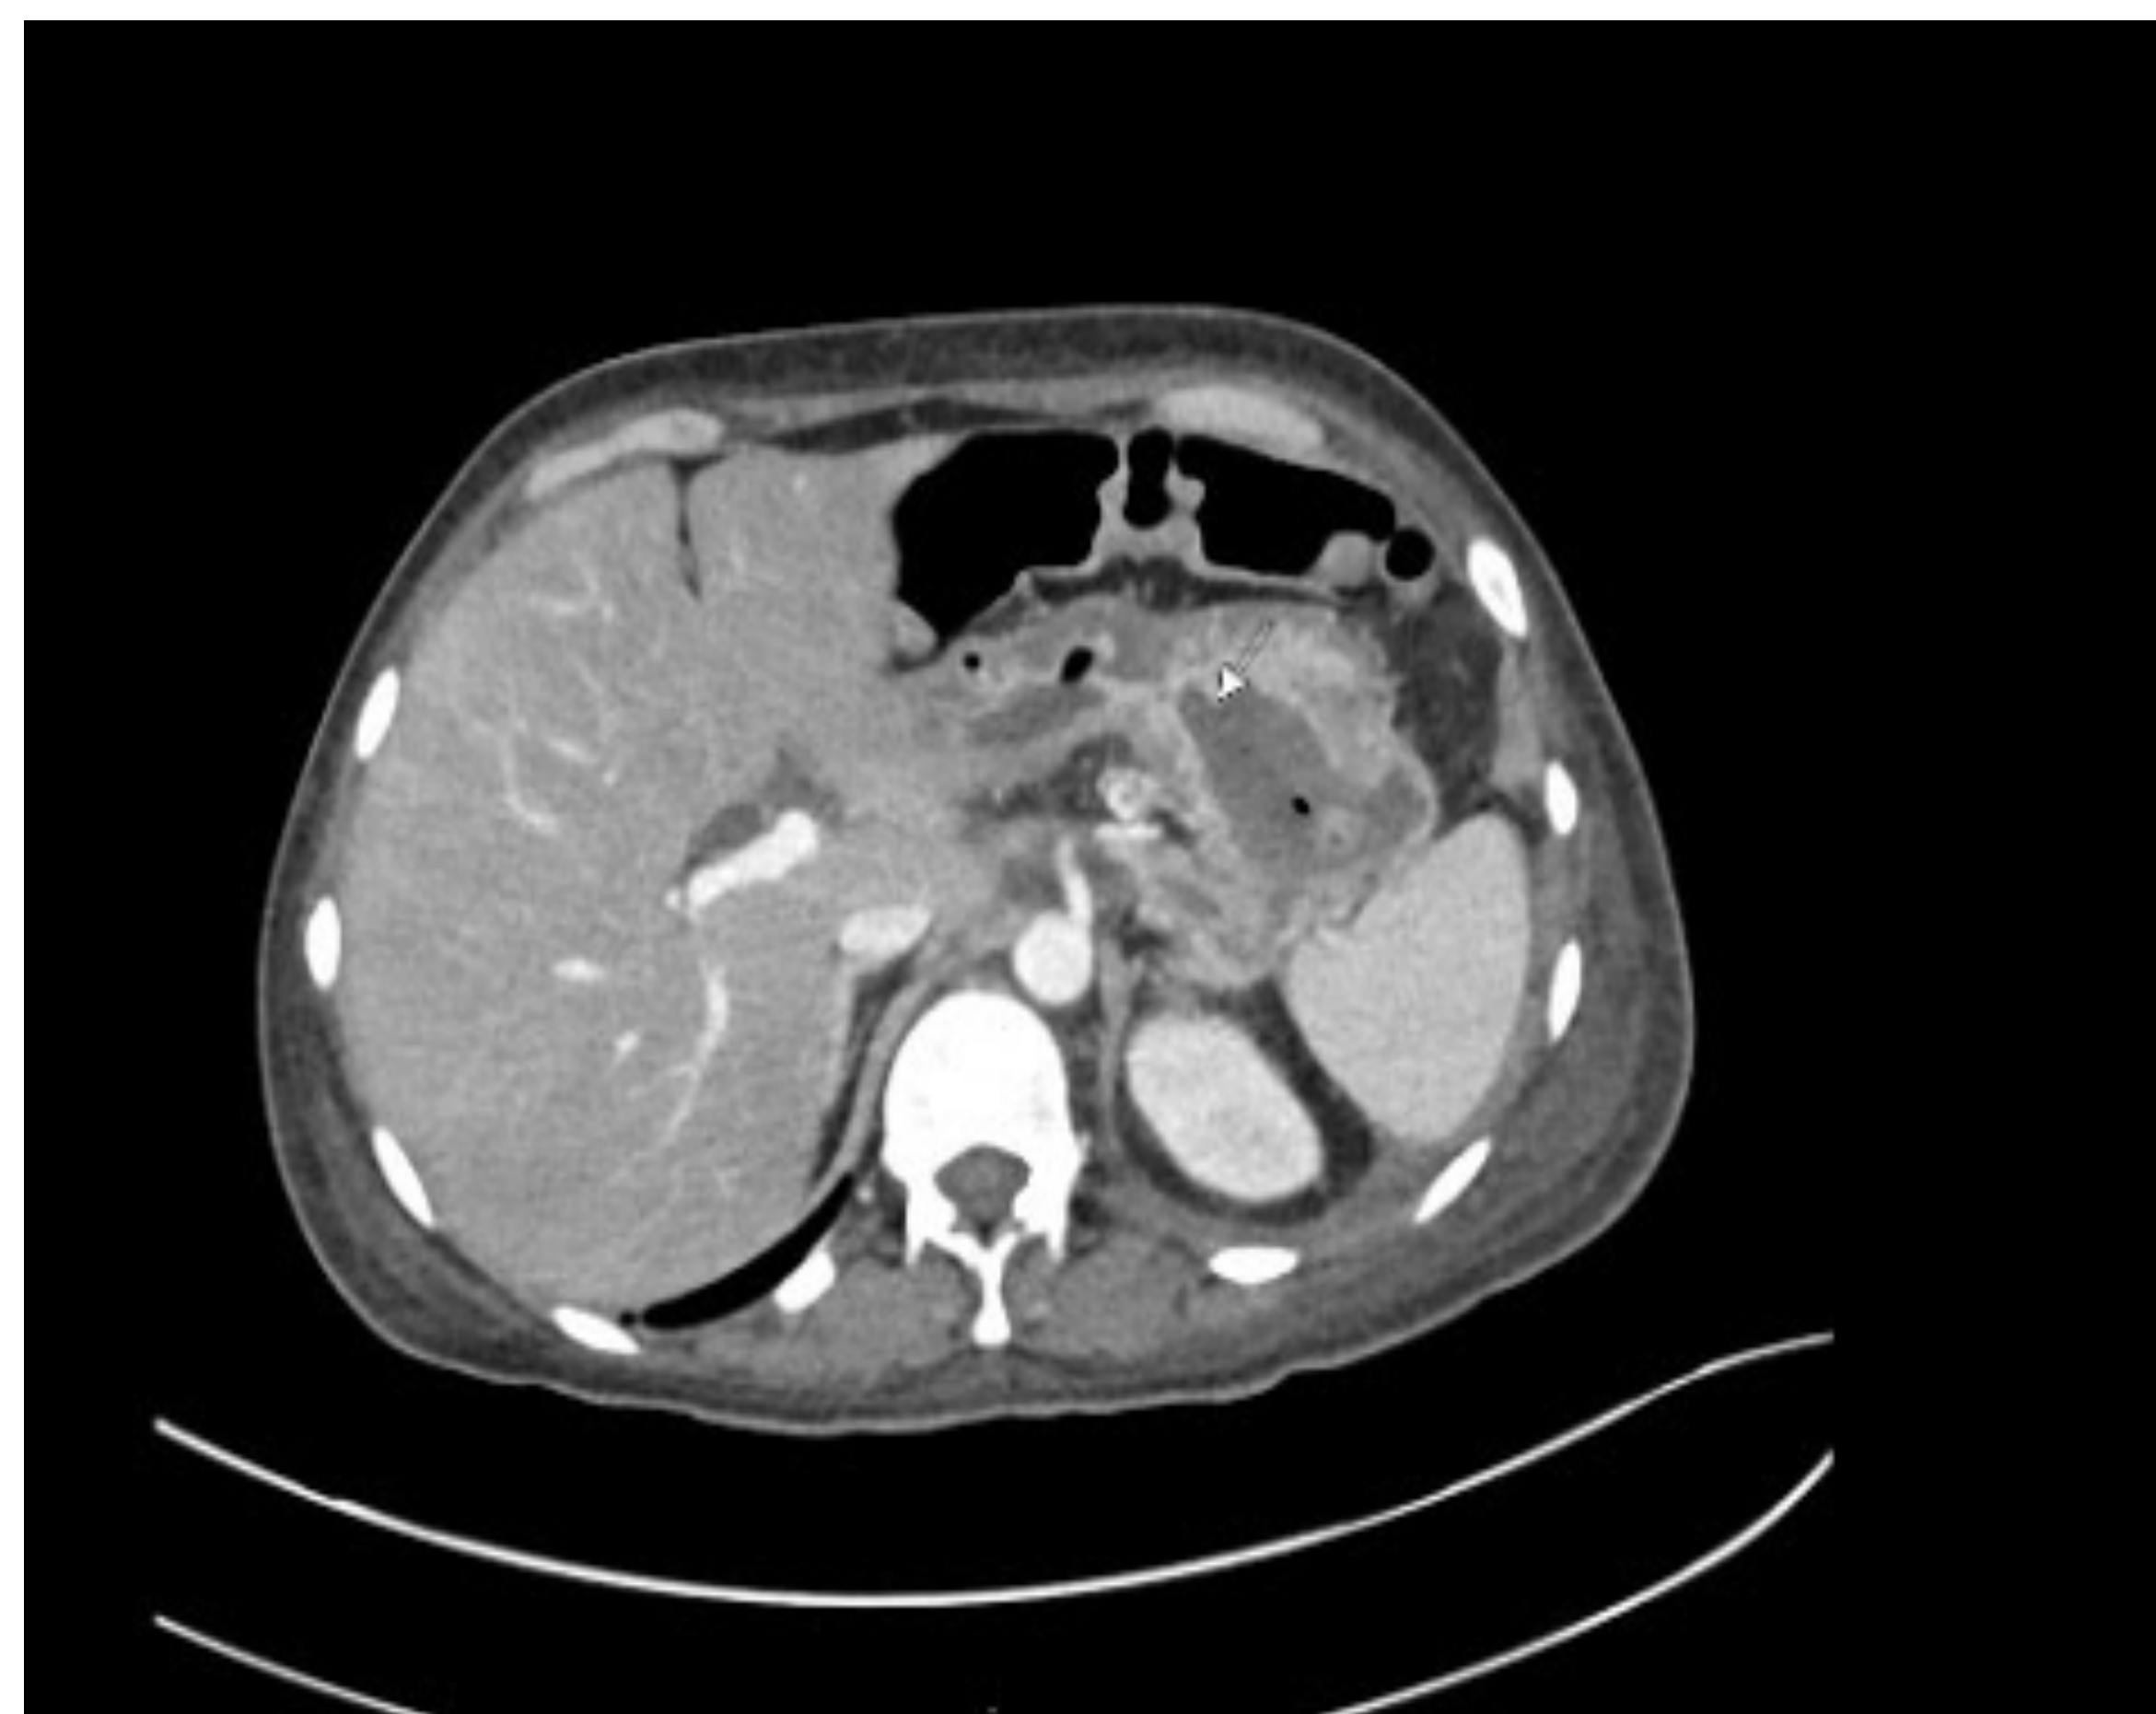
CT abdomen with Iv contrast- Peripherally enhancing fluid collection in the left upper quadrant/gastric wall. There is a communication between this collection with the gastric lumen.
